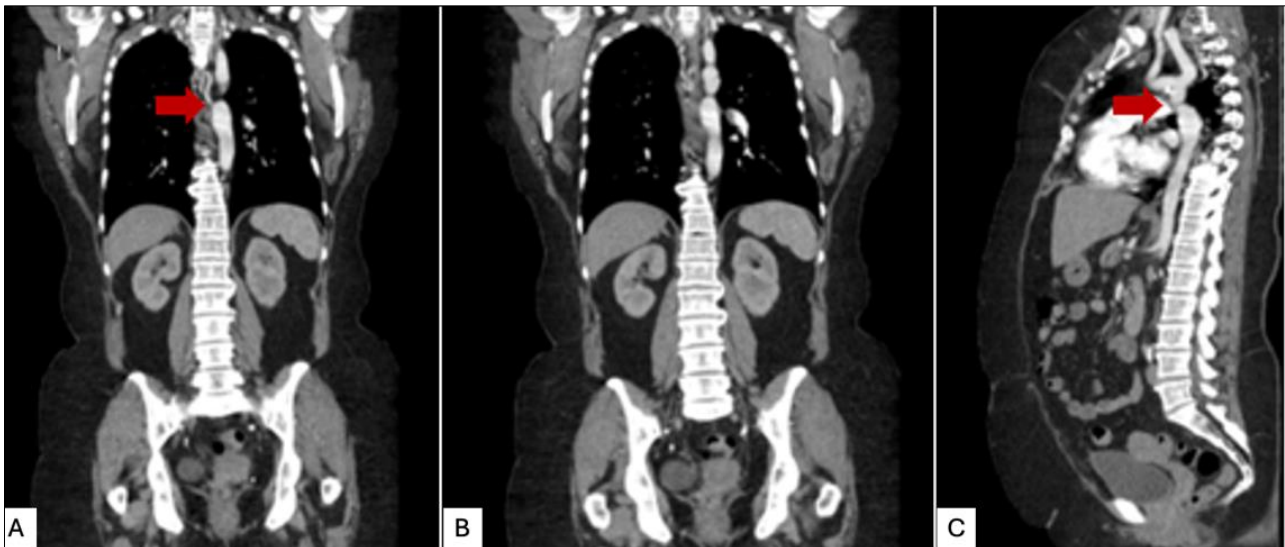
Contrast-enhanced CT angiography of the chest in coronal (A and B) and sagittal (C) sections showing type A interrupted aortic arch, evidencing loss of continuity between the aortic arch distal to the origin of the left subclavian artery and the descending thoracic aorta (arrows)
